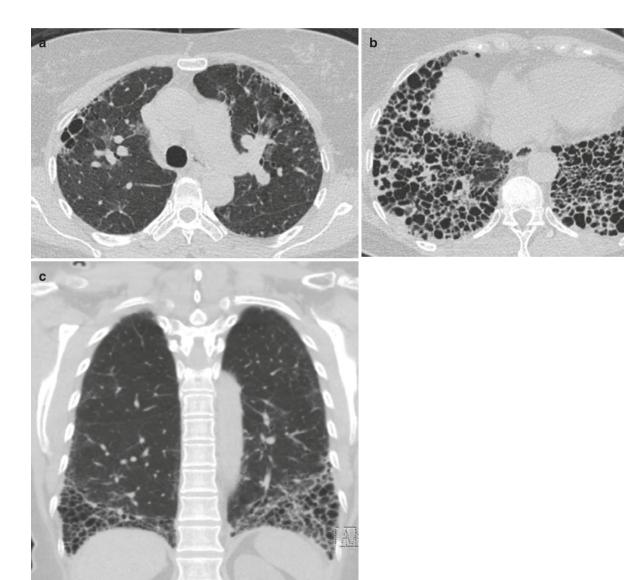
HRCT signs of CTD-UIP. (a) "Anterior upper lobe" sign, (b) "exuberant honeycomb," (c) "straight-edge" sign in a patient with UIP from RA
